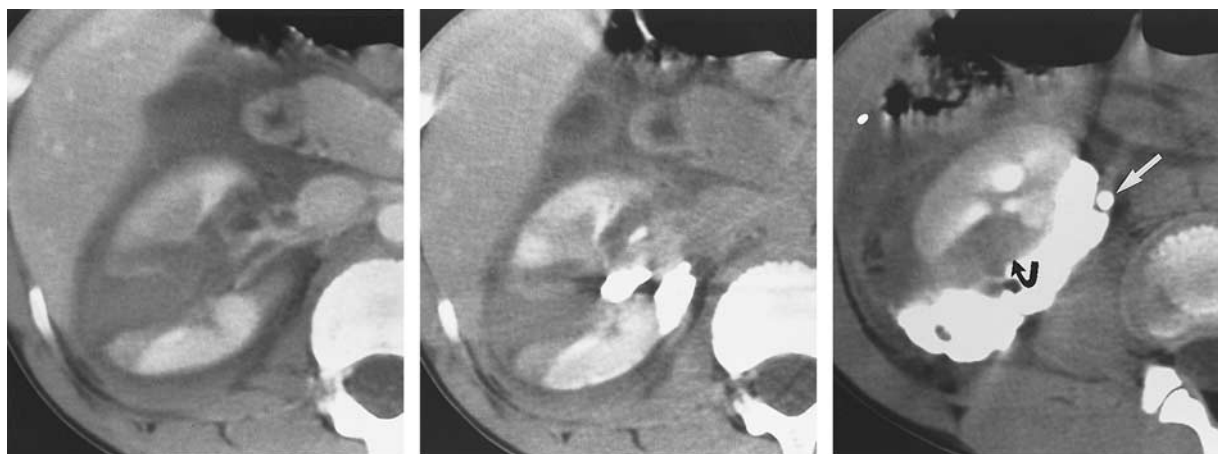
Major renal laceration involving the collecting system (category II) in an 8-year-old boy who had sustained blunt abdominal trauma. (a) Contrast-enhanced nephrographic-phase CT scan shows a large, distracted renal fracture through the interpolar portion of the right kidney. (b) Contrast-enhanced excretory-phase CT scan shows extravasation of contrast material from a laceration of the renal pelvis into the medial perinephric space. (c) Delayed CT scan shows extensive extravasation around the lower pole of the right kidney. Note the antegrade filling of the ureter (white arrow). A small laceration is also seen in the lower pole (black arrow). (Fig 13 reprinted, with permission, from reference 19.)
